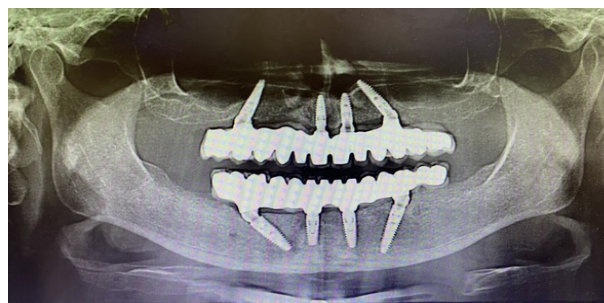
Follow-up radiograph four years post-surgery.
